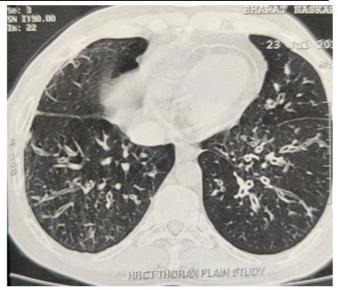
HRCT chest showing bilateral lower lobebronchiectasis(shown by arrow).
